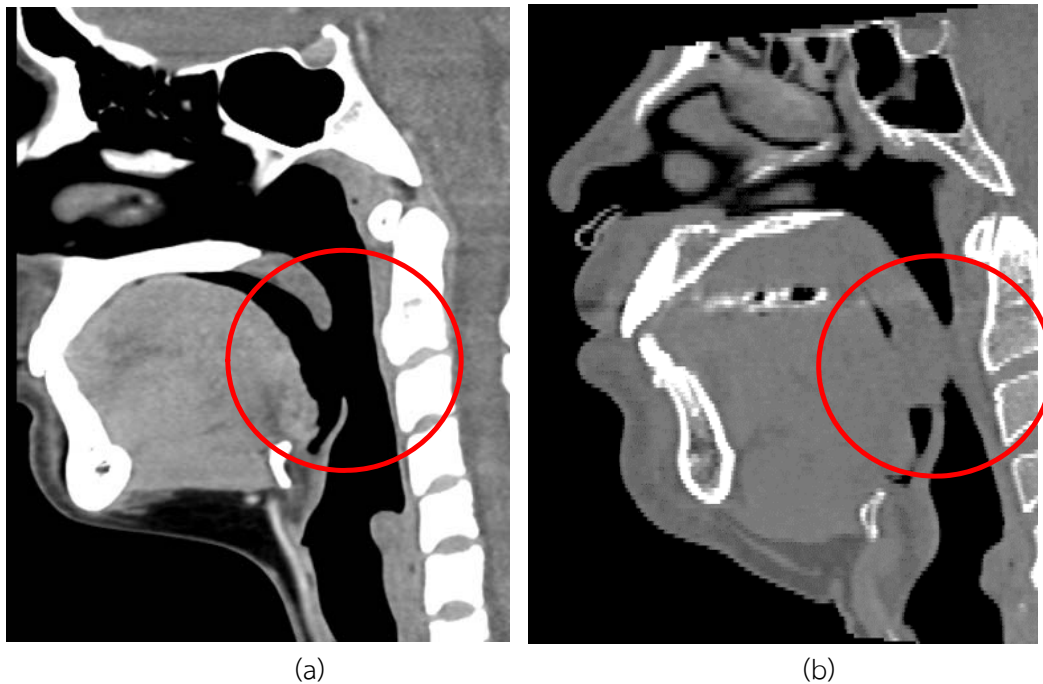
CT image of upper respiratory tract, compare the red circle which is constricted region (a) normal airway structure and (b) abnormal airway structure
